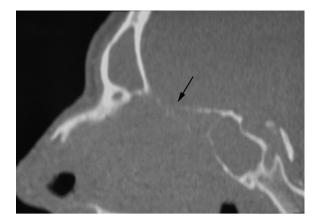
CT scan of the sinuses, bone window setting, sagittal section. The arrow indicates osteolysis of the roof of the anterior part of the ethmoid sinus.
